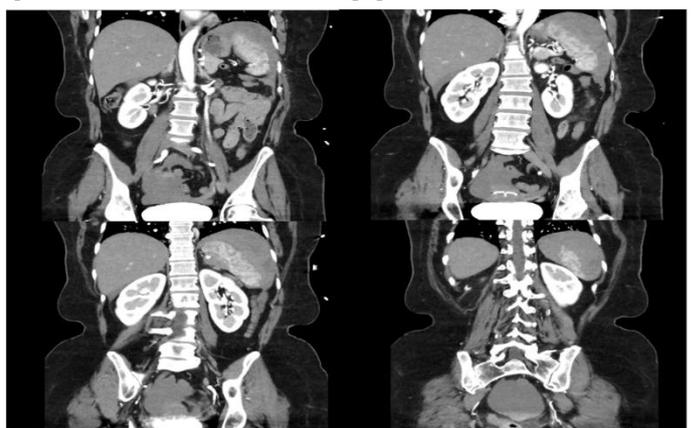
Coronal films of CT Mesenteric angiogram
